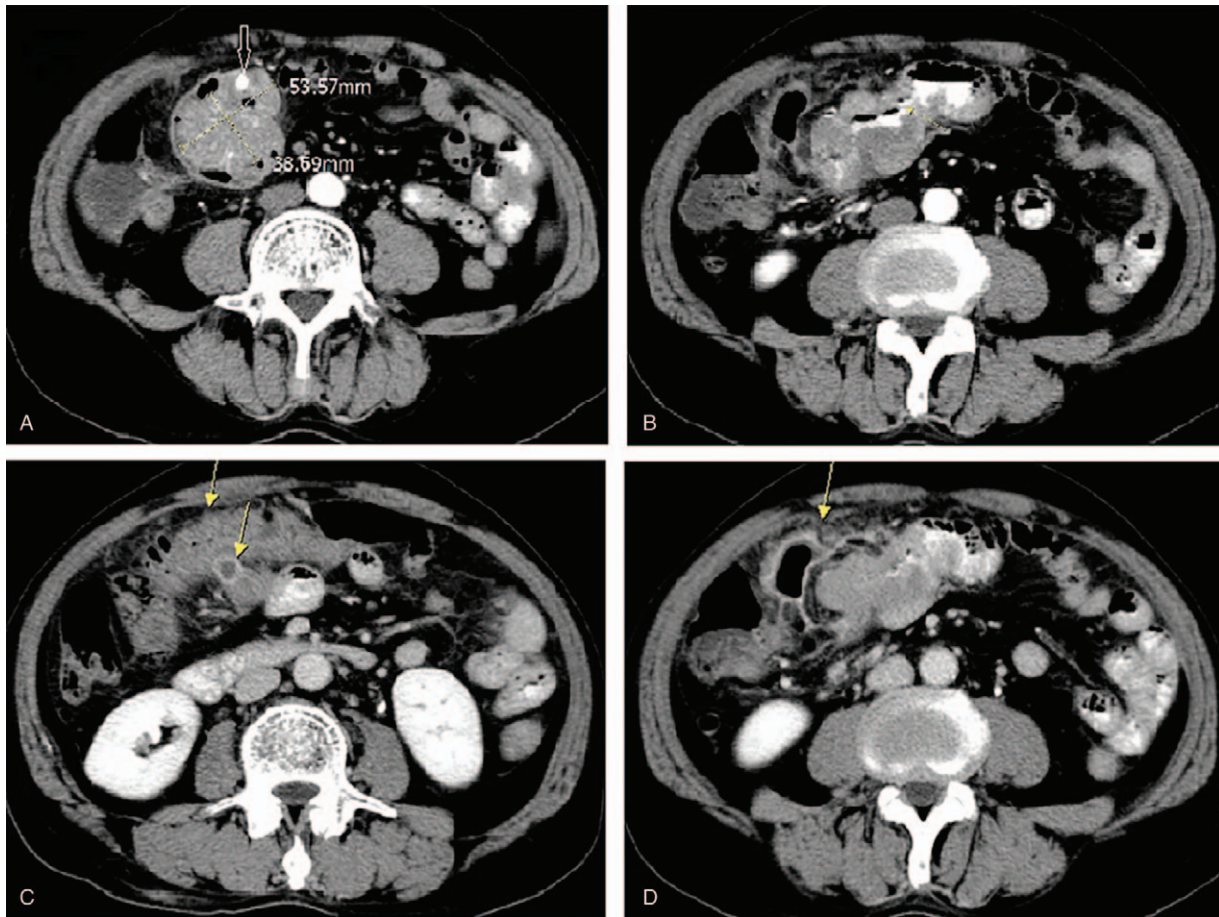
The patient came to our hospital for the first time and found abdominal mass. Axial contrast CT image (A) shows a neoplasm of small intestine with nodular calcification (coarse arrow), which size was about 39×54 mm and surrounds by intestinal tube. The mass is locally connected to the intestinal canal, as shown in the arrowhead (B). The tumor is surrounded locally by flocculent thickened or nodular like peritoneum (C, D). CT= computed tomography.
